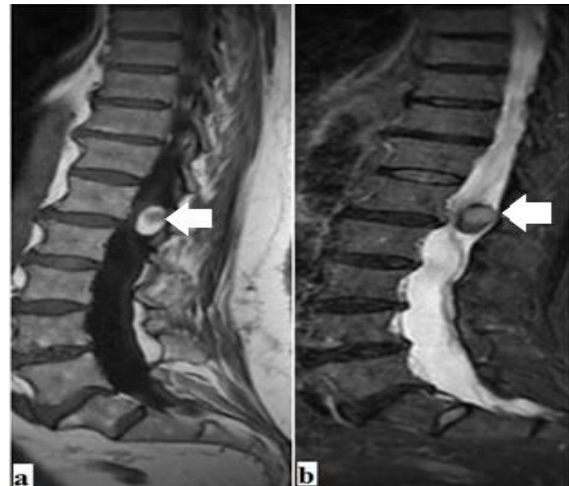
Dermoid cyst, MRI LS spine, (a) Sagittal T1W image and (b) STIR sequence showing intradural extra-medullary lesion with fat and soft tissue component at L1-L2 level, just distal to conus.
